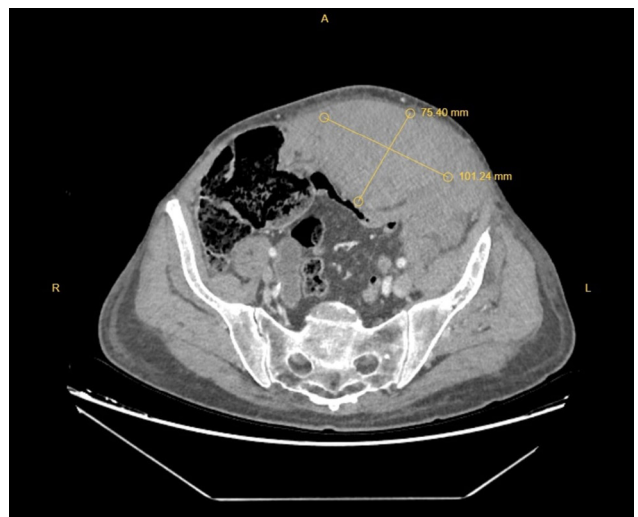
Axial computed tomography image of the abdomen pelvis with the diameter measurements of the left rectus sheath hematoma.
